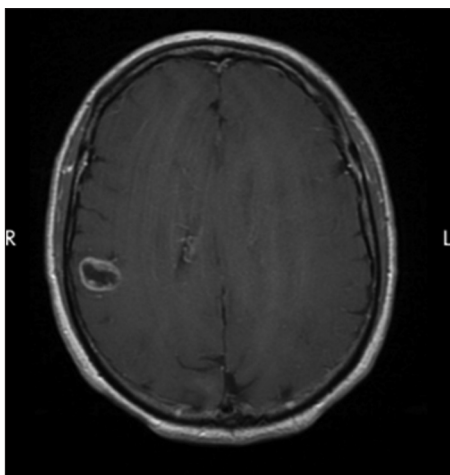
Magnetic resonance imaging brain T1 with and without contrast, horizontal section of the brain showing a ring-enhancing lesion in the right parietal lobe
